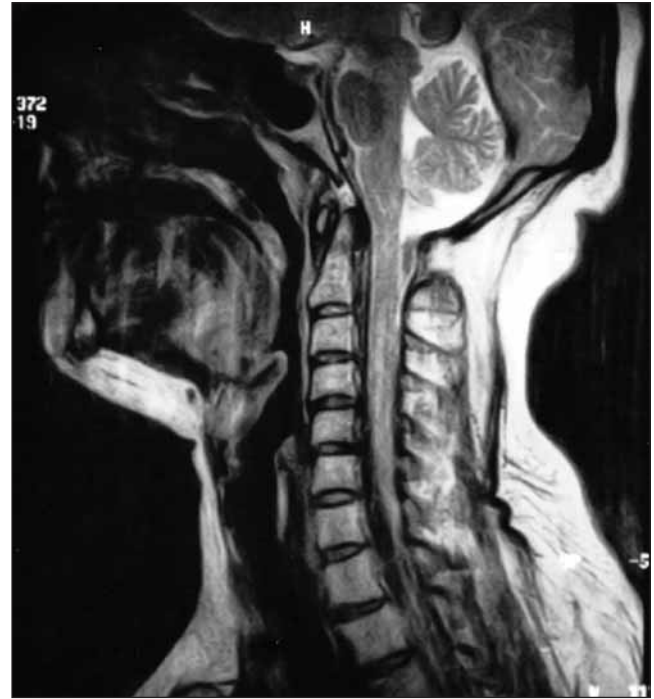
Sagittal T2 weighted MRI scan: Focal nodular thickening on the posterior wall of nasopharynx.
